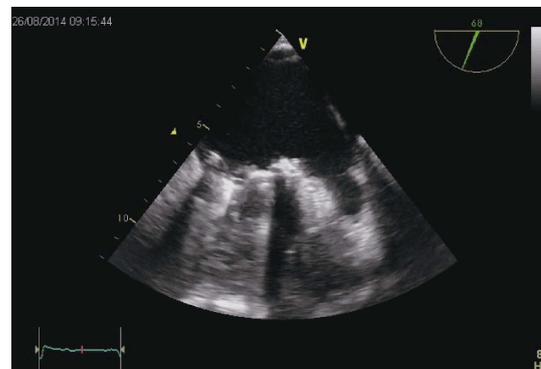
Transesophageal echocardiography: final position of the occluder.
